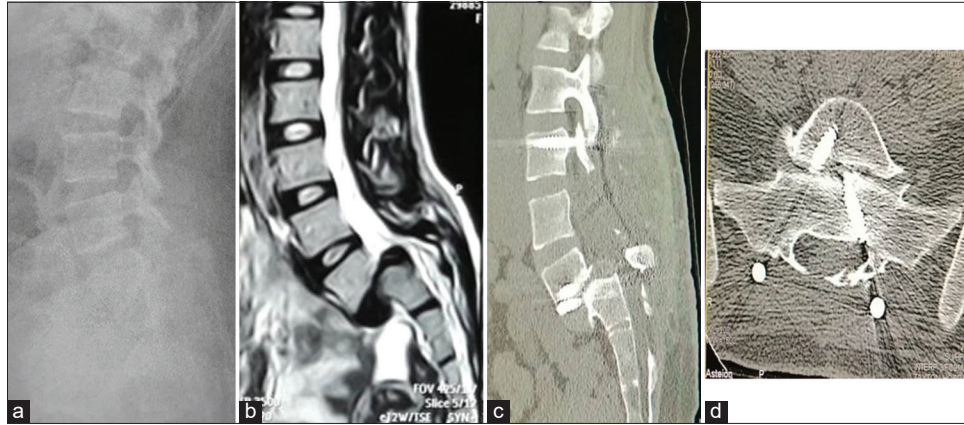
Female patient, house wife, 27 years old, presented by low back pain, bilateral sciatica and flexion attitude. Pre-operative image; (a) Plain x-ray lumbar spine, lateral view, (b) MRI lumbo-sacral spine, sagittal view showing HGS. Post-operative images CT lumbo-sacral spine, (c) sagittal view, showing the screws and limit of its reach, (d) axial view showing triangular arrangement of the transvertebral screws, 16 months following surgery.
